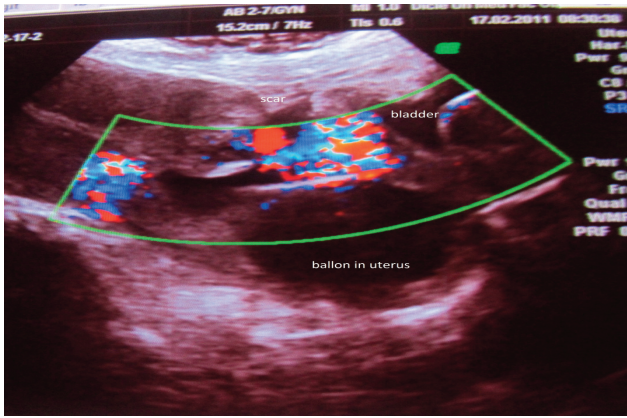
Ultrasonographic view of the CSP in Case 1. A Foley catheter has been placed in the uterine cavity to manage the profuse vaginal bleeding.
